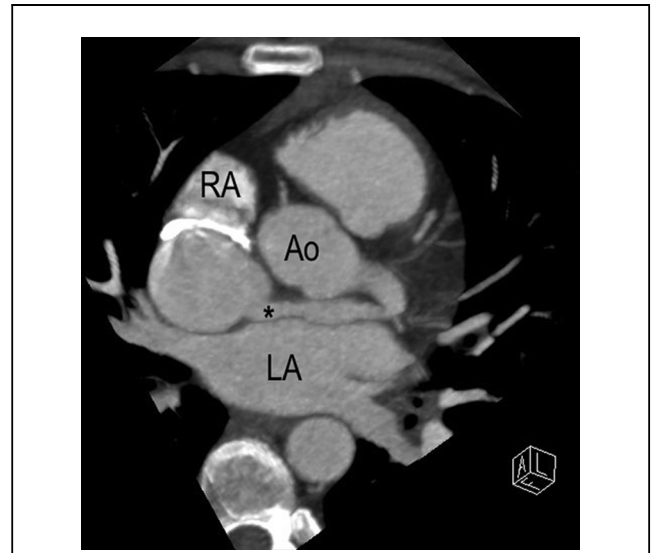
Axial Oblique CTA Image
